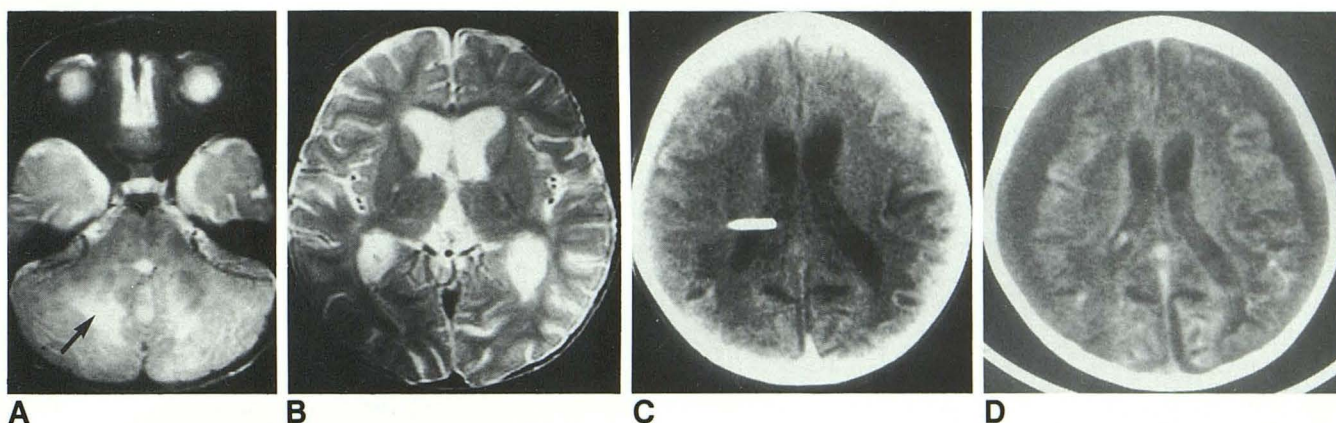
Case 2, 16-month-old girl with PAID; 1 month history of attacks of myoclonic fits with unconsciousness. A and B, Initial MR (T2-weighted) shows widened sulci and ventricles and extensive white matter changes in the posterior fossa (arrow).
